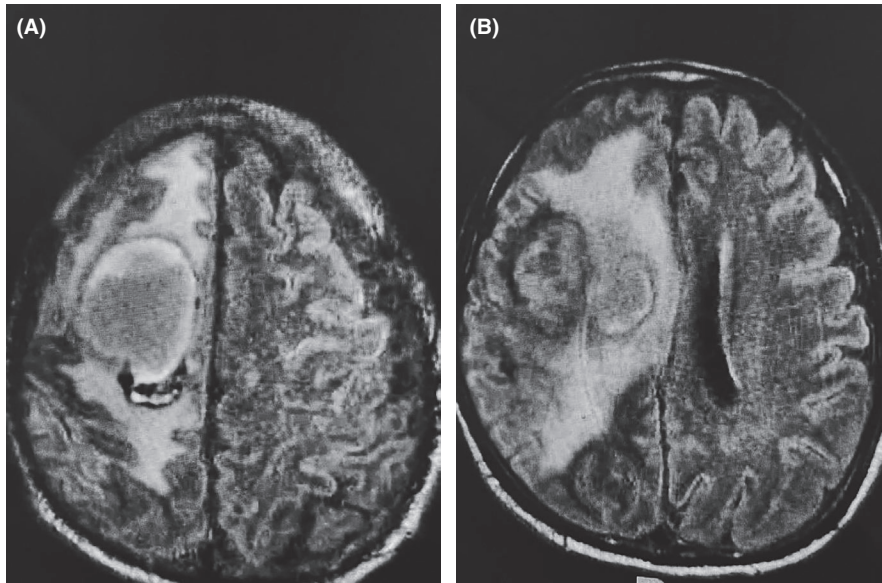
A, B MRI T2 Flair images
